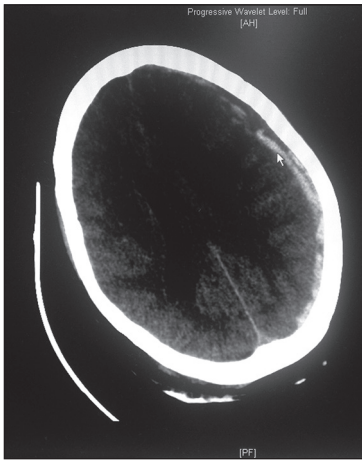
Non-contrast computed tomography head of the patient showing fronto-temporal subdural hematoma (white arrow)
